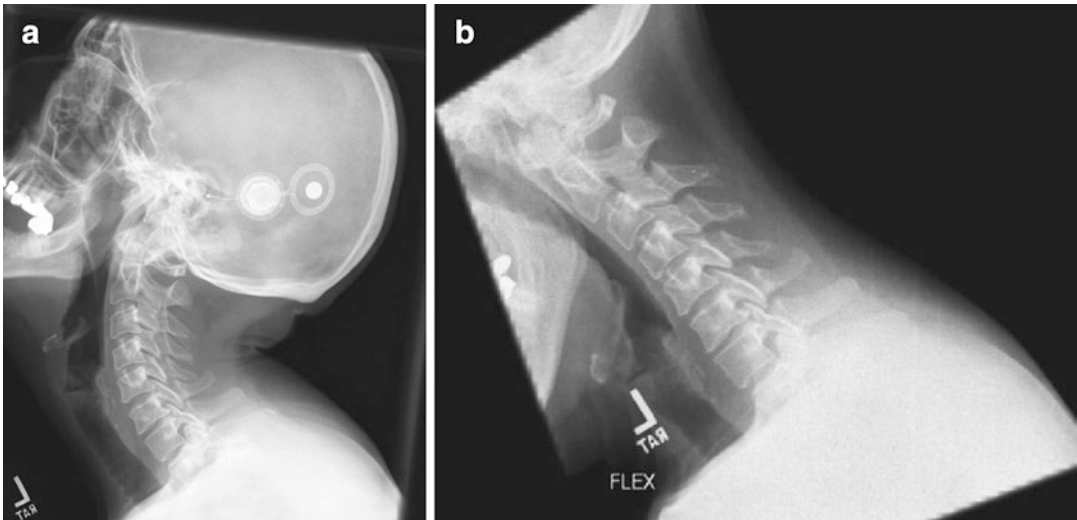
(a) Extension radiograph C-spine. (b) Flexion radiograph C-spine
